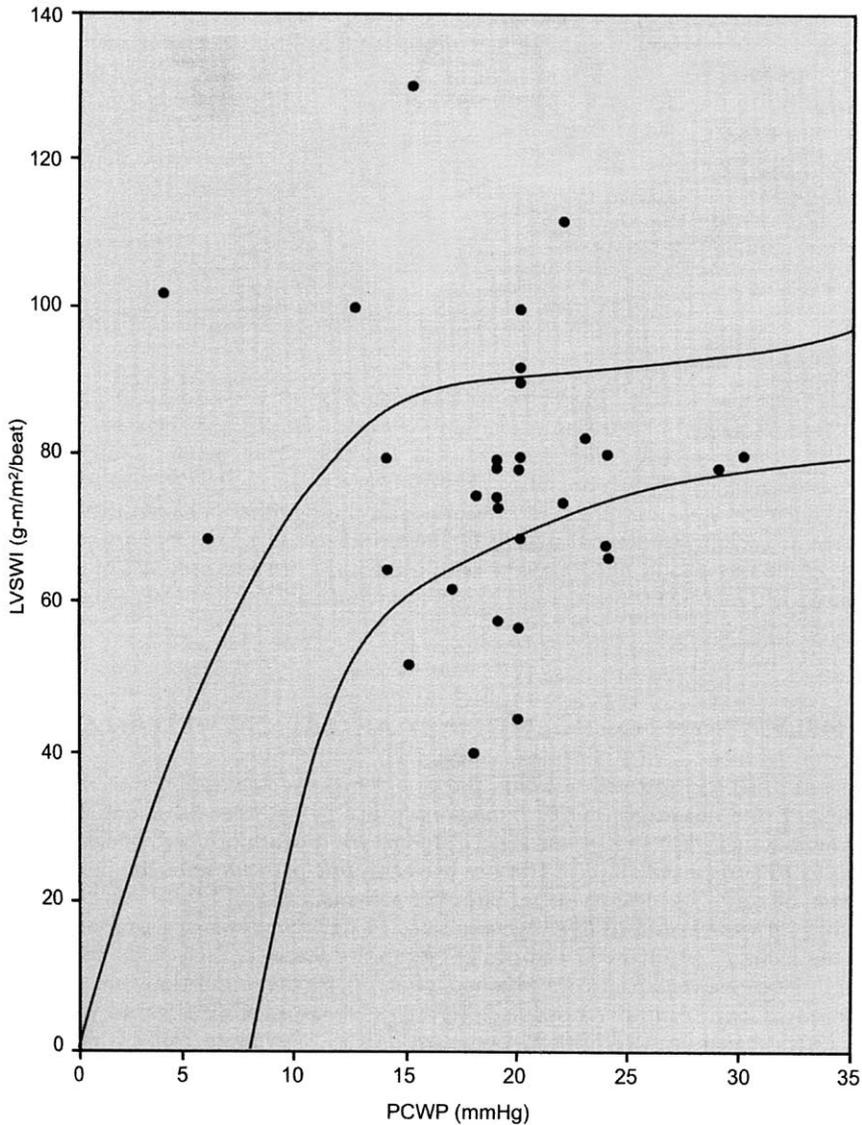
Left ventricular function curve in 32 patients with pulmonary edema. (From Young P, Johanson R. Haemodynamic, invasive and echocardiographic monitoring in the hypertensive parturient. *Best Practice & Research Clinical Obstetric and Gynecology* 2001;15:605–22; with permission.)
